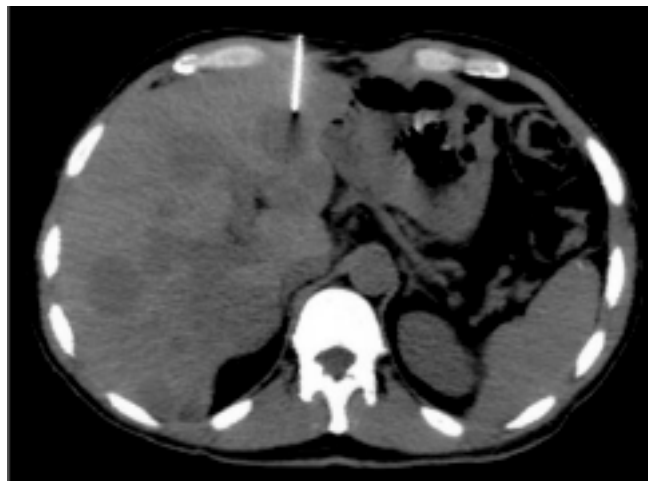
CT-guided liver biopsy from one of multiple hypodense lesions of secondary lymphoma.
